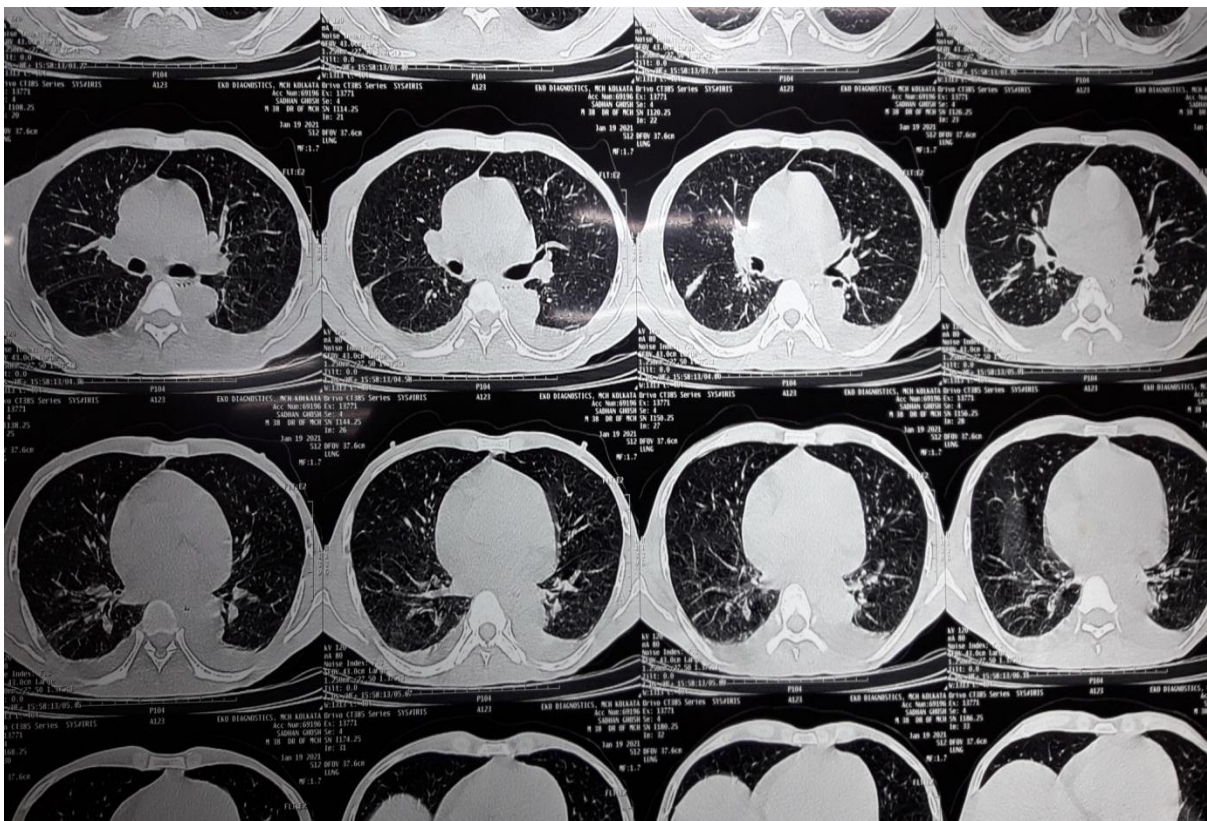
HRCT thorax showing b/l pleural effusion.
